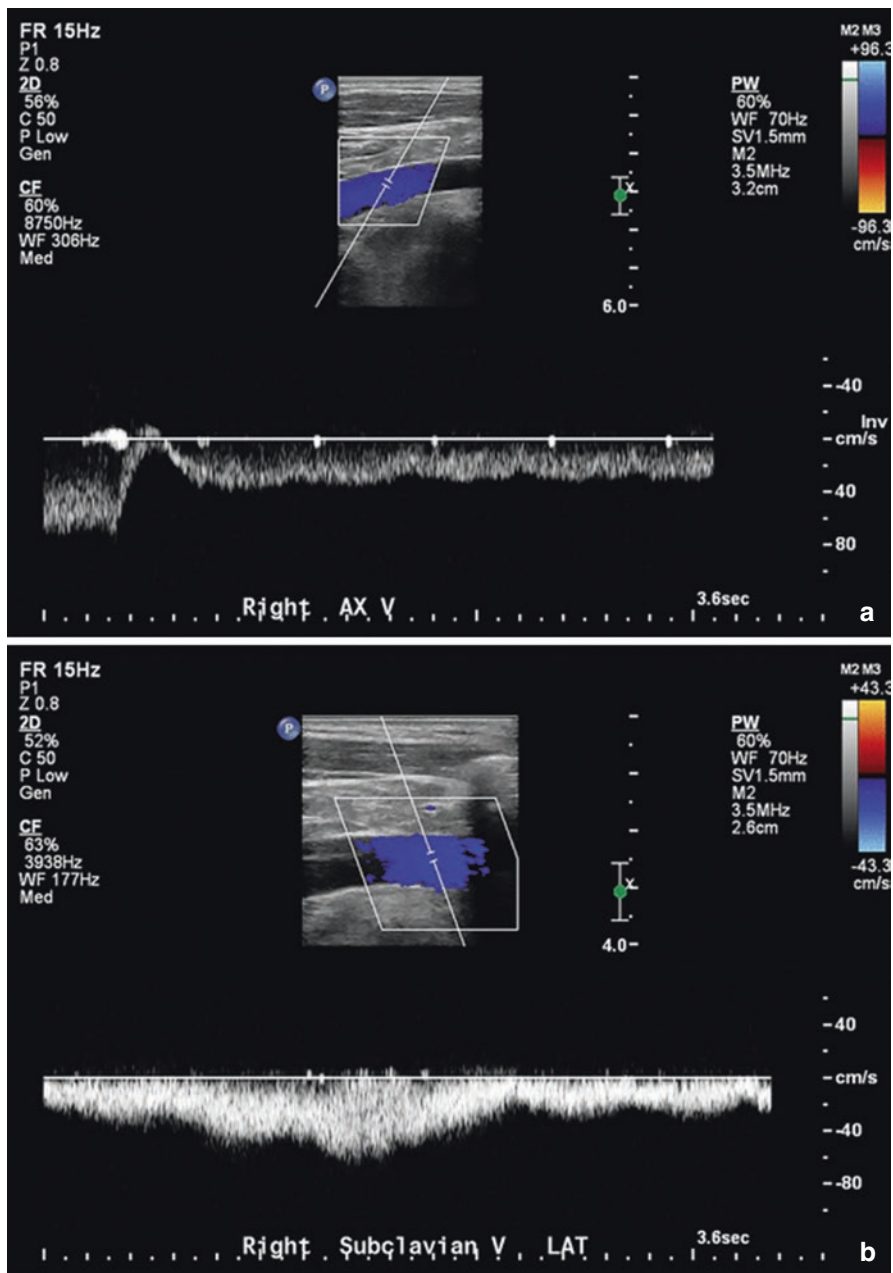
Normal duplex Doppler images of more central venous structures including the axillary (a), subclavian (b and c) and innominate veins (d). These are frequent areas of stenosis in patients with a history of prior dialysis access or other chronic indwelling catheters
